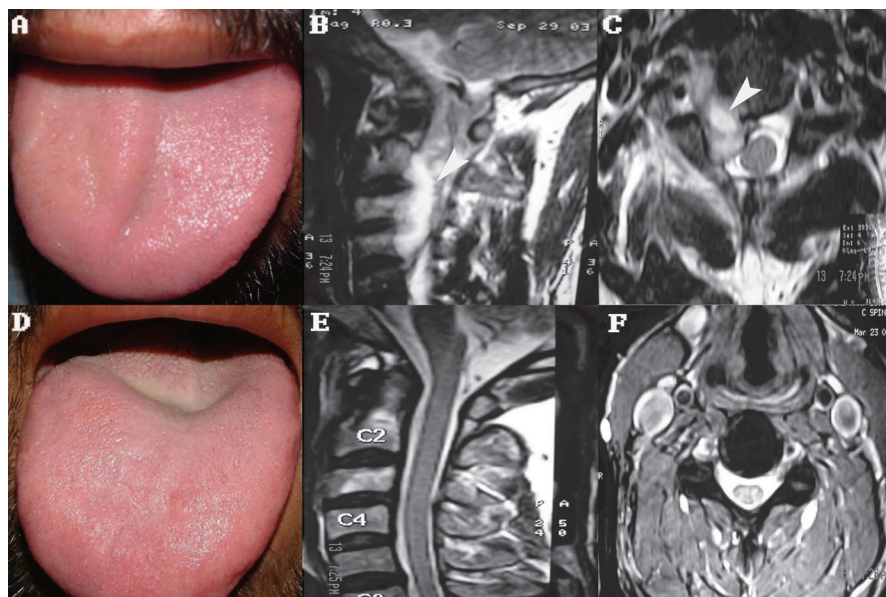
(A) Deviation of tongue to right side with atrophy on the right side. (B and C) Sagittal and axial sections of MRI, T2-weighted image showing large epidural abscess extending from C1 to C4 predominantly on the right side (arrow, B) and extending to neural foramina (arrow, C). There is evidence of destruction of C3 vertebral body with normal intervertebral disc space. (D, E, F) After 1.5 years of antitubercular treatment. (D) Improvement in tongue deviation and muscle bulk on the right side. (E and F) Sagittal and axial section of MRI, T2-weighted image showing regression of epidural abscess with residual hyperintense signal of C2 and C3 vertebral bodies.
